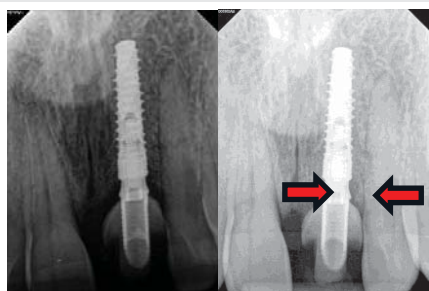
Periapical x-rays: (a) after implant placement and (b) two months post-crown.
